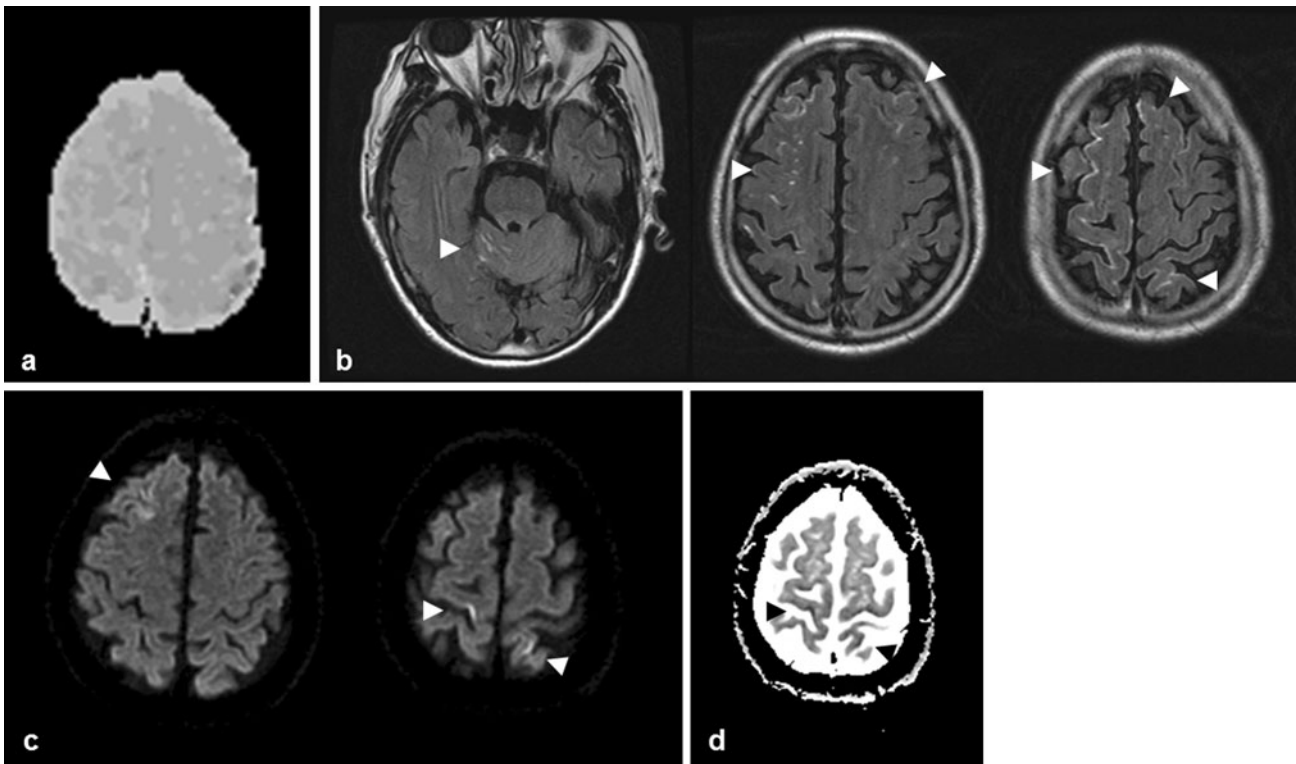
Brain MRI of the patient. a The time-to-minimum-perfusion map demonstrates no perfusion deficit. b FLAIR images obtained 2 h after symptom onset show postgadolinium CSF enhancement.
